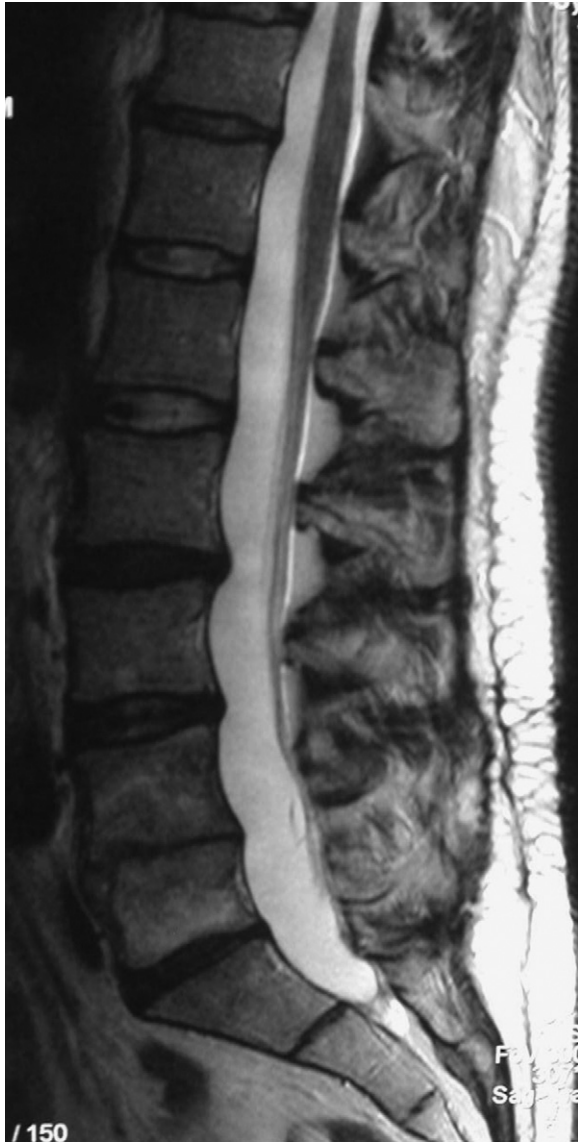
Sagittal T2-weighted MR image of the lumbar spine in 2002 showing a clumping of nerve roots and an “empty-sac” appearance.
